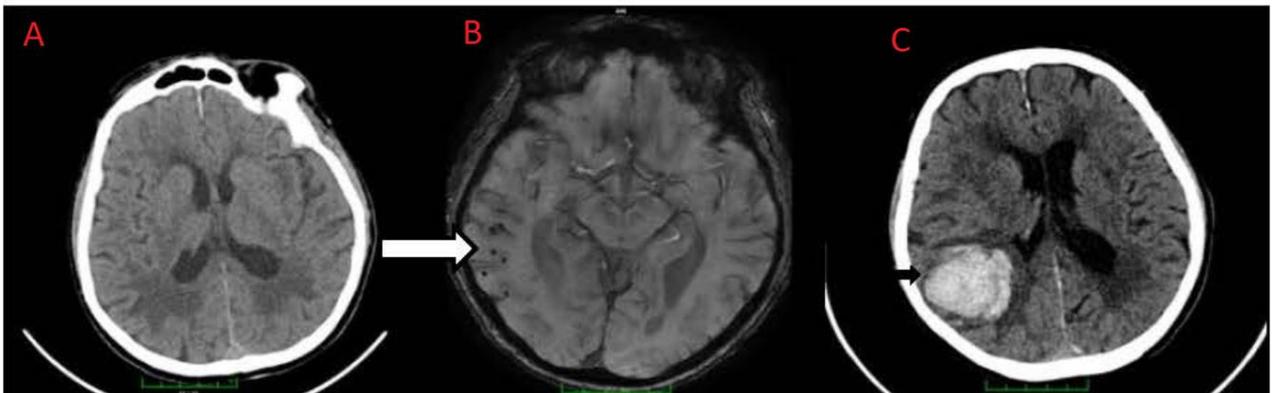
A 72-year-old male patient who presented with headache and left hemihypoesthesia. A. Periventricular diffuse ischemic changes on brain CT, B. The MRI of the same patient obtained 5 months later because of left hemiplegia that developed while receiving warfarin for deep vein thrombosis. Microhemorrhages are visualized in the SWI sequence, C. Lobar hemorrhage on brain CT (thin arrow).
